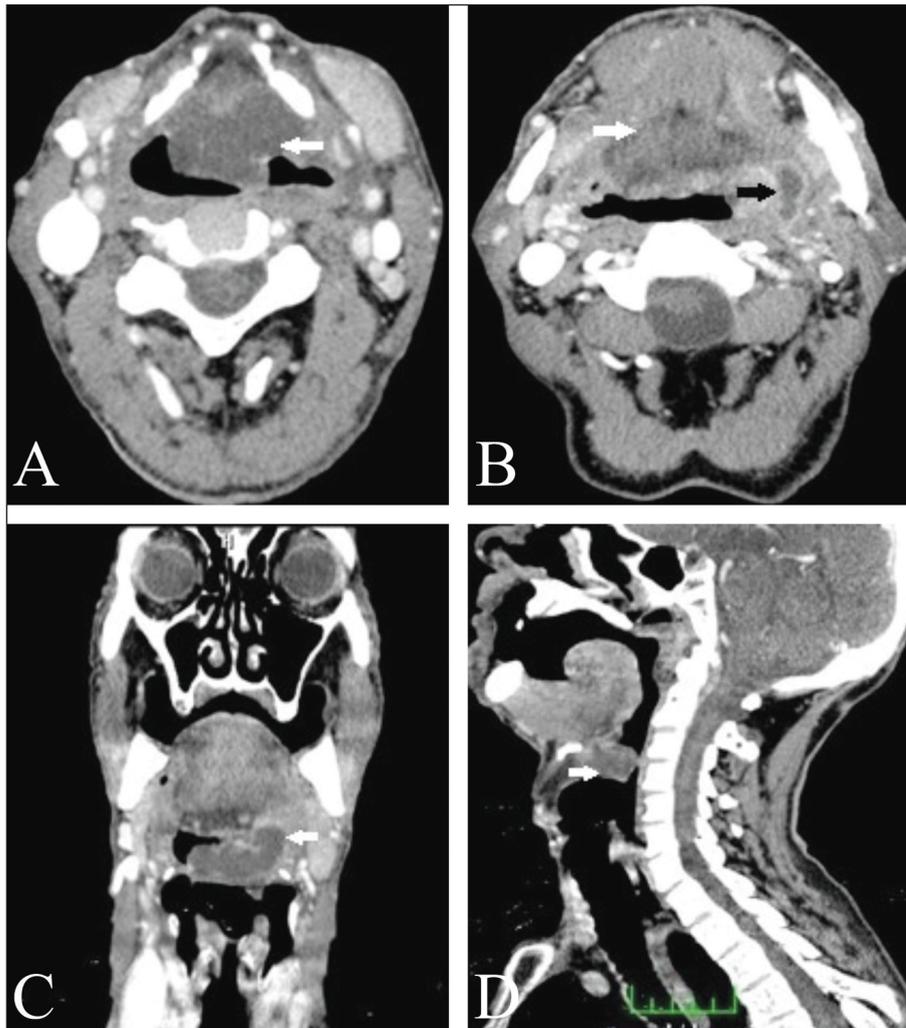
Contrast-enhanced neck computed tomography images [white arrows indicate the abscess (A, B, C, D) and black arrow indicates the part of the abscess extending to the left parapharyngeal area (B)].
